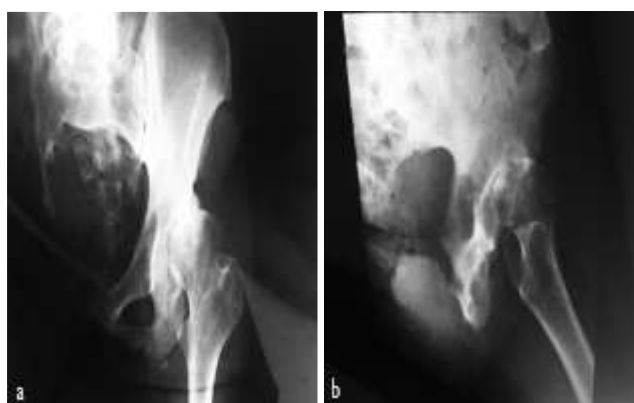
(A and B): Ap and lateral X-ray of left hip in supine position. Hip osteoarthritis Tonnis III with proximal subluxation of femoral head is evidenced.
